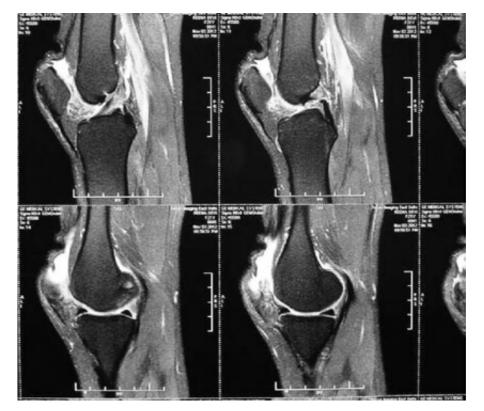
MR imaging - T2 weighted images showing discontinuity at quadriceps insertion.
